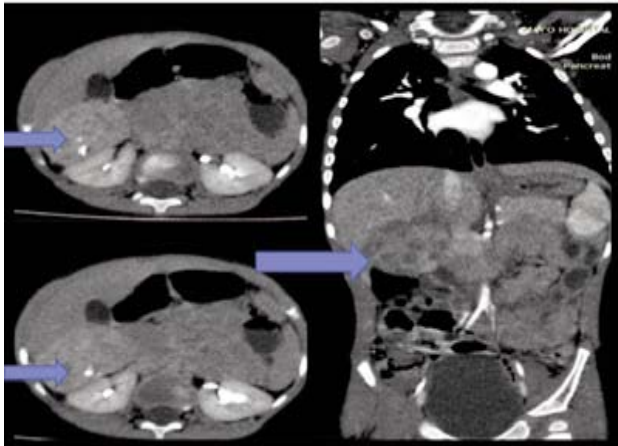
Post chemotherapy abdominal Computed Tomography (CT) showing 70% reduction in tumor size, with the arrow showing suprahepatic location of the tumor
